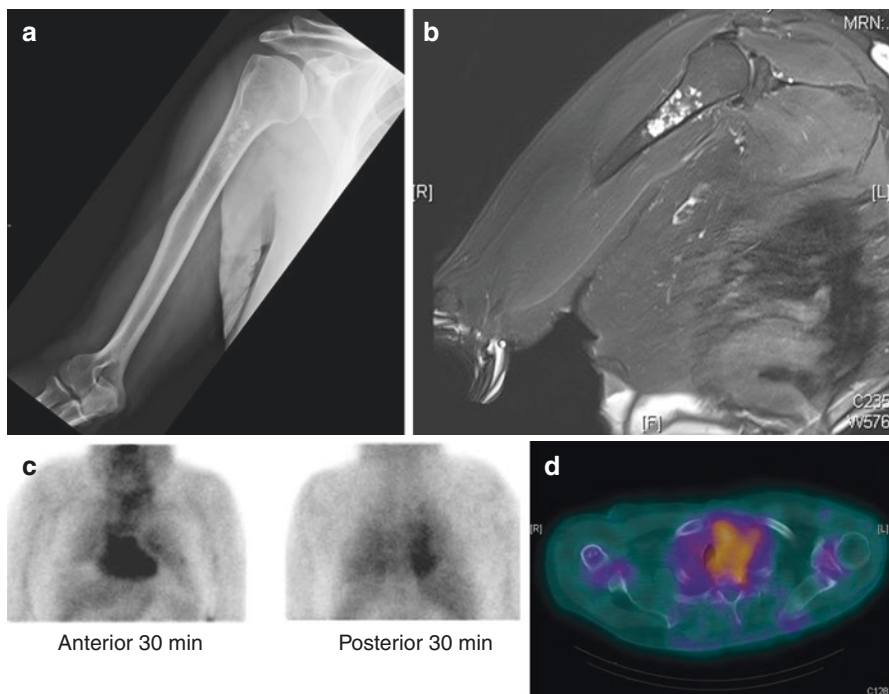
(a) A 71-year-old male with right shoulder pain, plain X-ray demonstrating typical chondroid-type calcification involving the proximal right humerus. (b) T2 coronal MRI showing high signal consistent with cartilage. (c) Planar DMSA(V) images show no tracer uptake in the right humeral lesion. (d) SPECT/CT DMSA(V) image confirms no tracer activity within the lesion consistent with a benign enchondroma
